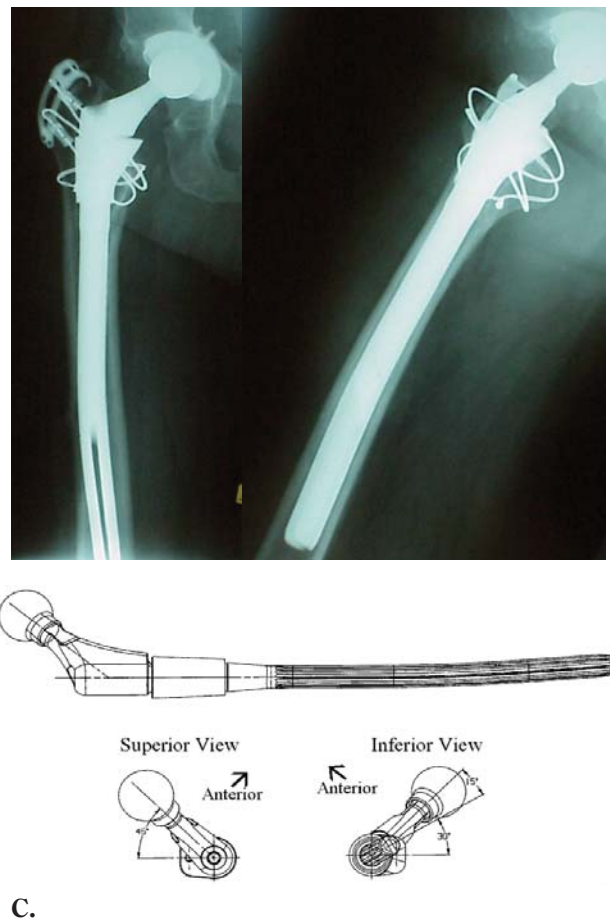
A/P radiograph (A), lateral radiograph (B) and corresponding model (C) demonstrating lateral placement of distal stem bow. Metaphysis is rotated 45° from the centerline of the neck and is seated in 30° of retroversion. Apex of Stem bow faces straight laterally.
